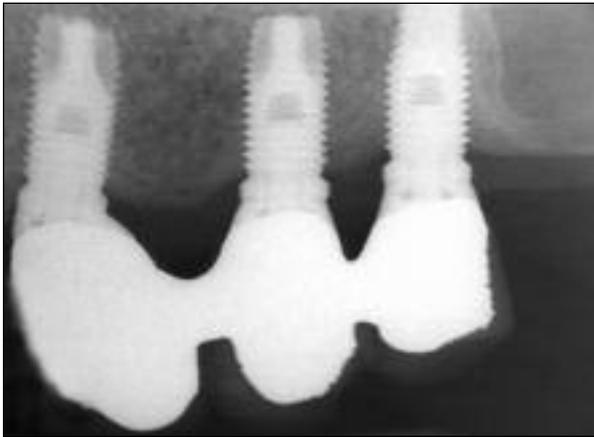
Radiograph showing three definitive splinted restorations in the maxillary left quadrant at the time of abutment and prosthesis placement.
